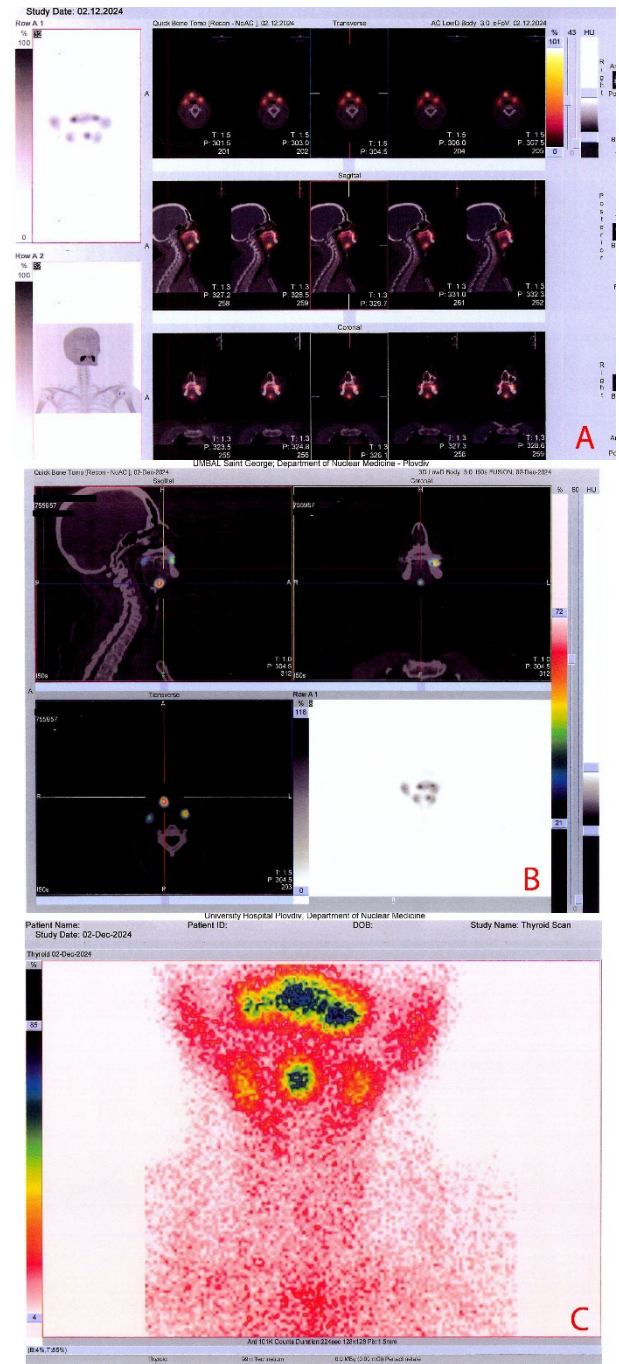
A and B. Hybrid SPECT/CT images demonstrate focal uptake of ^{99m}Tc-pertechnetate in the sublingual region, localized between the submandibular salivary glands. C. Planar scintigraphic image showing the same focal tracer accumulation. No radiotracer uptake is observed in the pretracheal thyroid bed or elsewhere in the neck, consistent with ectopic sublingual thyroid tissue and absence of orthotopic thyroid gland
